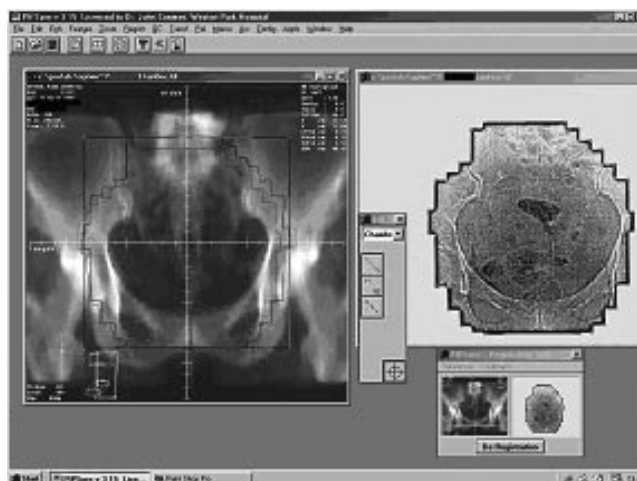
Workspace of the PIPSPRO (Standard Imaging) 2D image registration package. The treatment image on the right is an amorphous silicon portal image (Varian PortalVision), registered to a planned beam portal shown as a digitally reconstructed radiograph on the left (AcQSIM). Field outlines and anatomy have been defined by the user.
